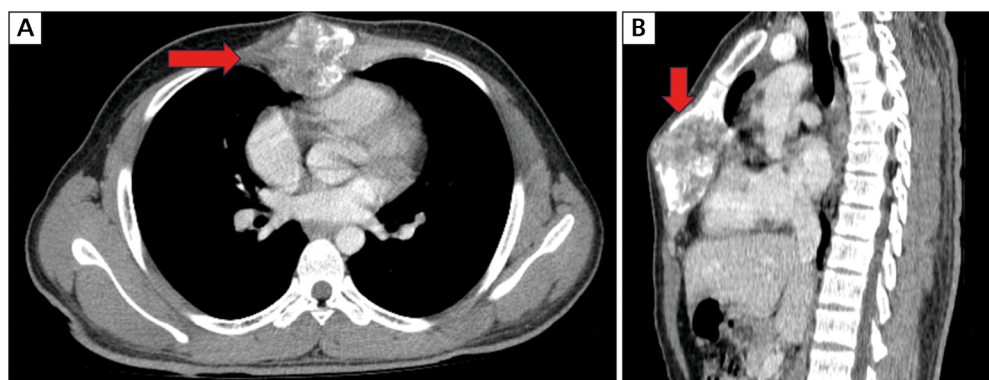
Computed tomography chest — expansile lesion involving the body of sternum (marked by red arrow) with an enhancing soft tissue component within the lesion showing significant rings and arc type of calcification and extension into adjacent soft tissue; A. Coronal; B. Sagittal
